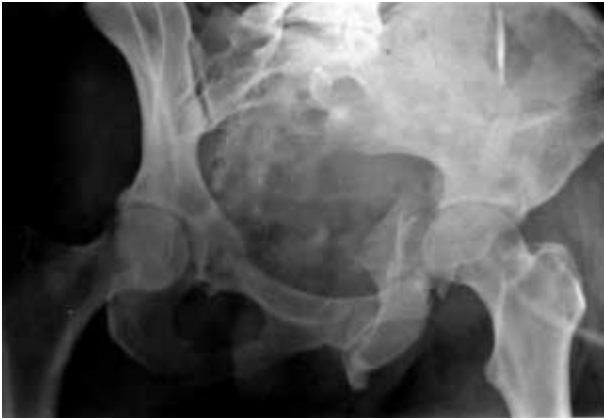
Preoperative x-ray of the pelvis showing an AO type C-3 fracture.
